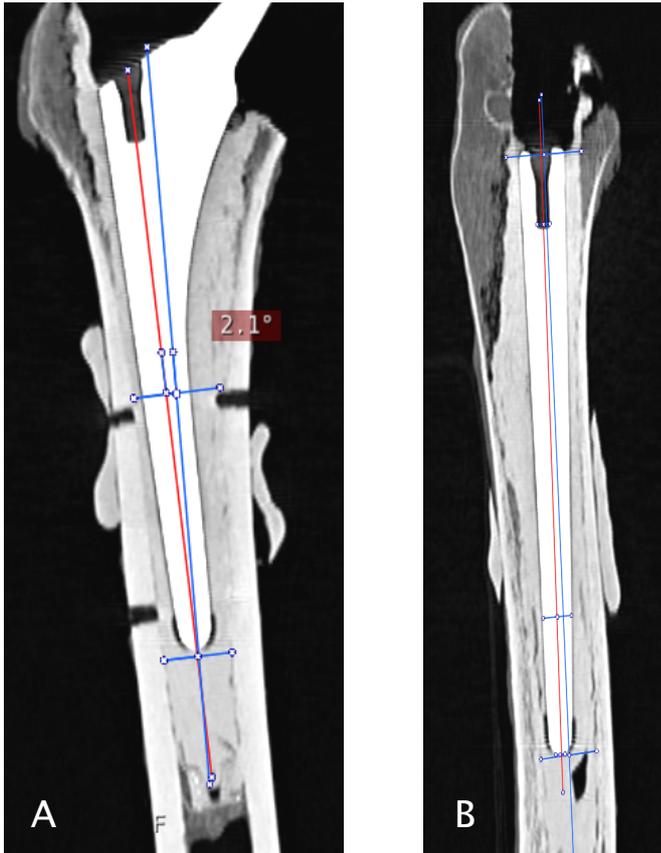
A-B. CT evaluation of femoral prosthesis. The axes of implant and femoral canal at both coronal (A) and lateral projections (B). Redline; axis of the femoral stem, blue line; femoral axis.
